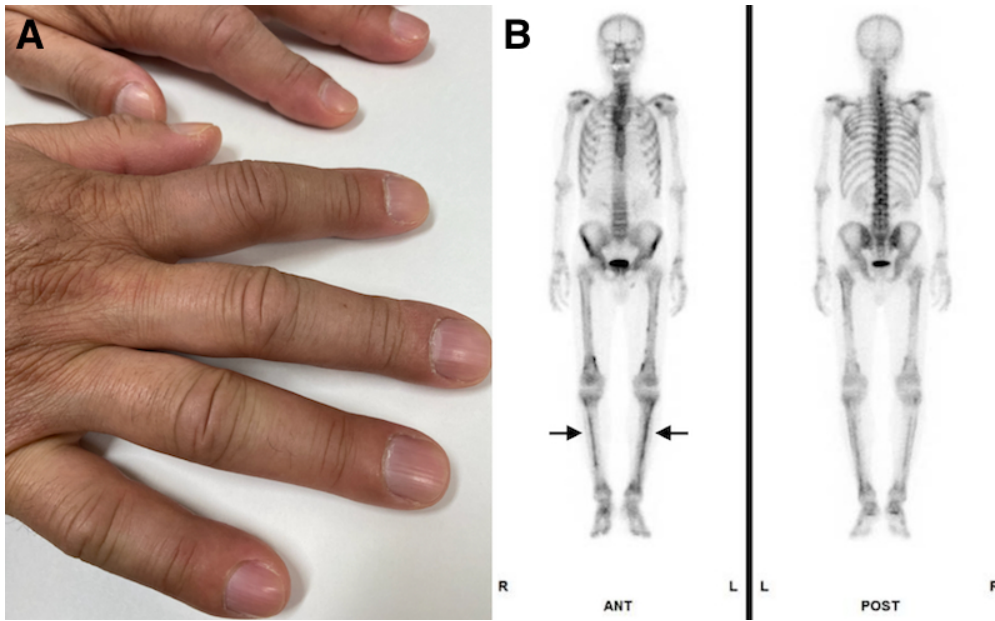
(A) The patient's fingers with mild clubbing. (B) Whole-body bone scintigraphy image showing increased uptake along the tibias (arrow).
